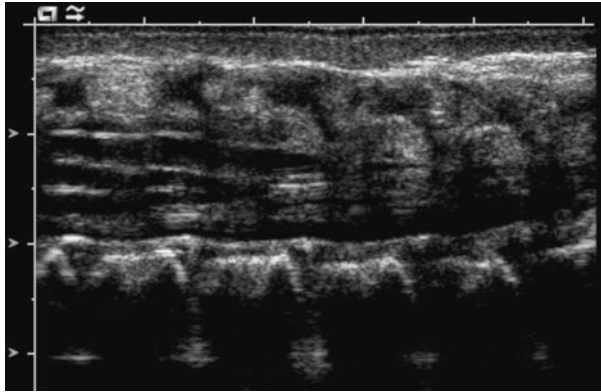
Ultrasound spine. US of the spine clearly depicts the cord, conus, and cauda equina. The position of the conus relative to the vertebral elements can be assessed and the presence or absence of spinal anomalies can be confidently determined. Spinal US is best performed before 6 weeks of age, when the relative lack of vertebral ossification allows for good visualization.
